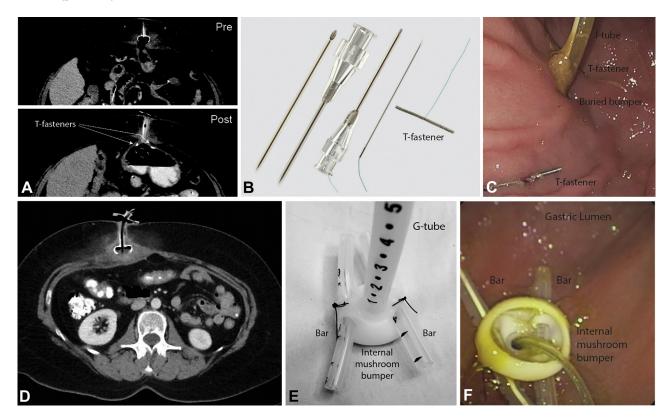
A, CT scan of the abdomen showing the internal mushroom bumper of a gastrostomy tube buried within the anterior abdominal wall with surrounding inflammation (Pre), and CT image after placement of 2 T-fasteners (Post). B, Cope gastrointestinal suture anchor set: 2 spring coil suture anchors (or T-fasteners), an introducer, and a loader (reproduced from the Cook Endoscopy Image Library). C, Endoscopic image showing 2 newly placed T-fasteners on either side of the gastrostomy site, the buried internal mushroom bumper (not shown), and the jejunostomy tube. D, CT scan of the abdomen showing the internal mushroom bumper of a gastrostomy tube (G-tube) buried within the anterior abdominal wall, with surrounding inflammation. E, Representative image of a manually enforced internal mushroom bumper of a new 24F G-tube by 2 added and sutured bars (2 segments of an 18F silicone jejunostomy tube). F, Endoscopic image showing 2 newly placed bars sutured to the internal mushroom bumper.
